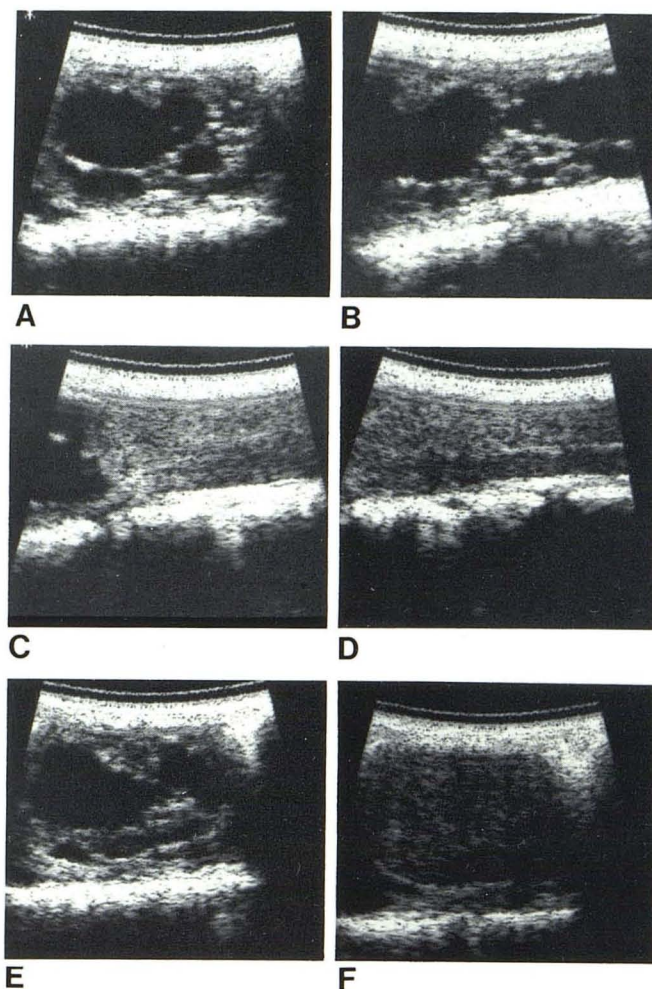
Sagittal transdural sonograms of ependymoma at various levels. C4 (A) and C5 (B). Multiple, well defined cysts of irregular shape and variable size correspond closely to low density in figs. 1D–1F and irregular density in figs. 1A–1C. C, Lower border of tumor characterized by more homogeneously echogenic area, with gradual transition to more normal, less echogenic spinal cord. There is appearance (or reappearance) of central spinal canal, which does not appear to be displaced. Obscuration of this structure was useful in delineating caudal tumor margin. Transverse sonograms confirmed cystic (E) and solid (F) nature of ependymoma and showed degree of cord enlargement well.
